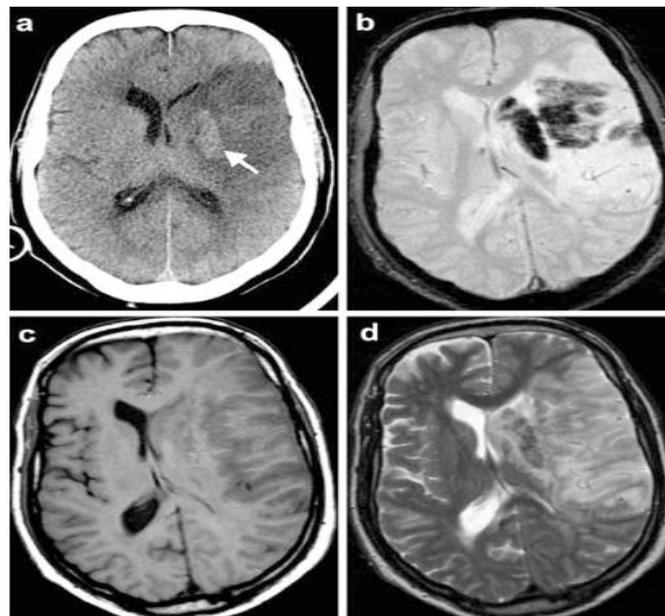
a–d Patient with an extensive infarct in the territory of the middle cerebral artery. The oval increased density in the left basal ganglia depicted on CT (arrow in a) could represent a spared lentiform nucleus. The MR images were obtained 3 days later. Haemorrhagic transformation is best depicted on T2*-weighted GE (dark areas in b). The haemorrhagic changes are underestimated on T1- (c) and T2-weighted (d) sequences.
